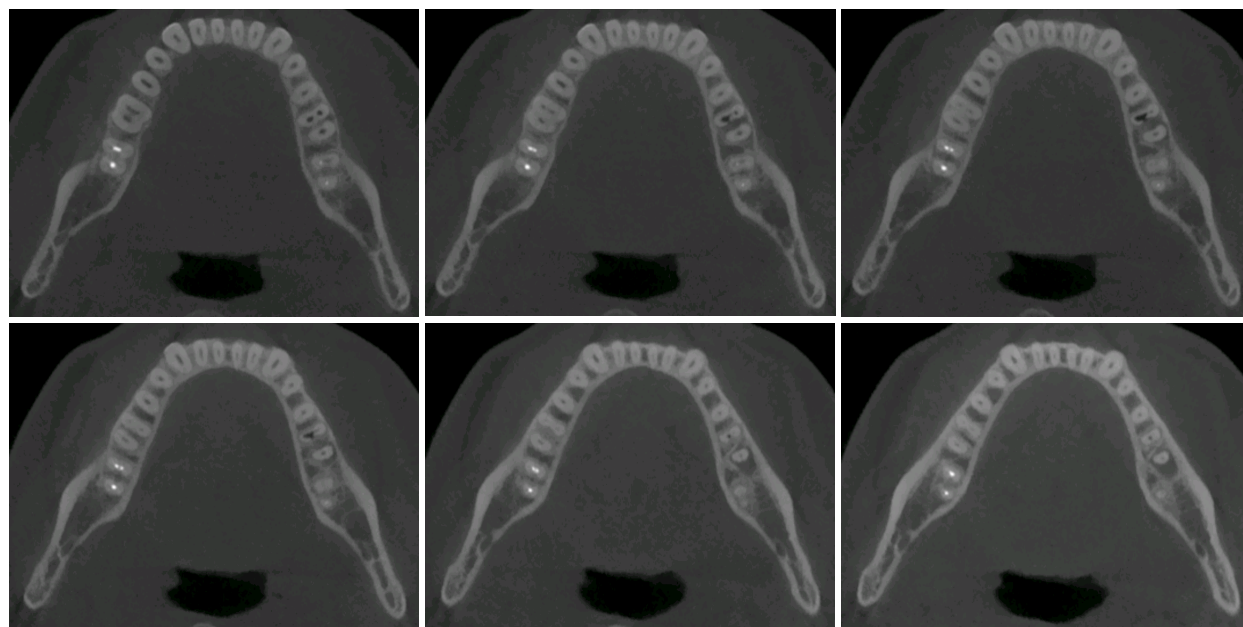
Preoperative CBCT scan (axial view revealing the distal extension of the IRR with detectable perforation in mesial root of tooth 36).
